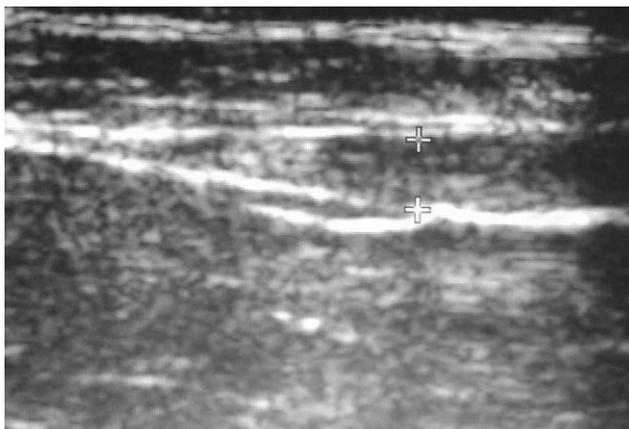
Example of an ultrasound still frame of the transverse abdominal muscle
